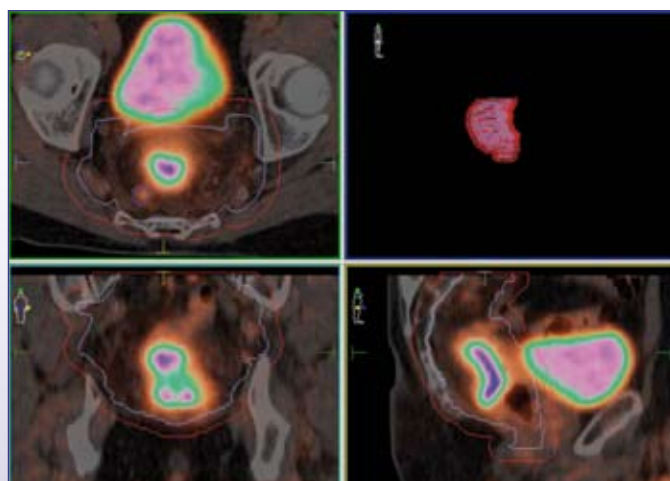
Delineation of the GTV, CTV and PTV on the basis of a  $^{18}\text{F}$ -FDG PET-CT from a patient with a mid rectal cancer. GTV is light brown, the enlarged PET-positive mesorectal lymph node is blue, the CTV is light blue and the PTV is red.
